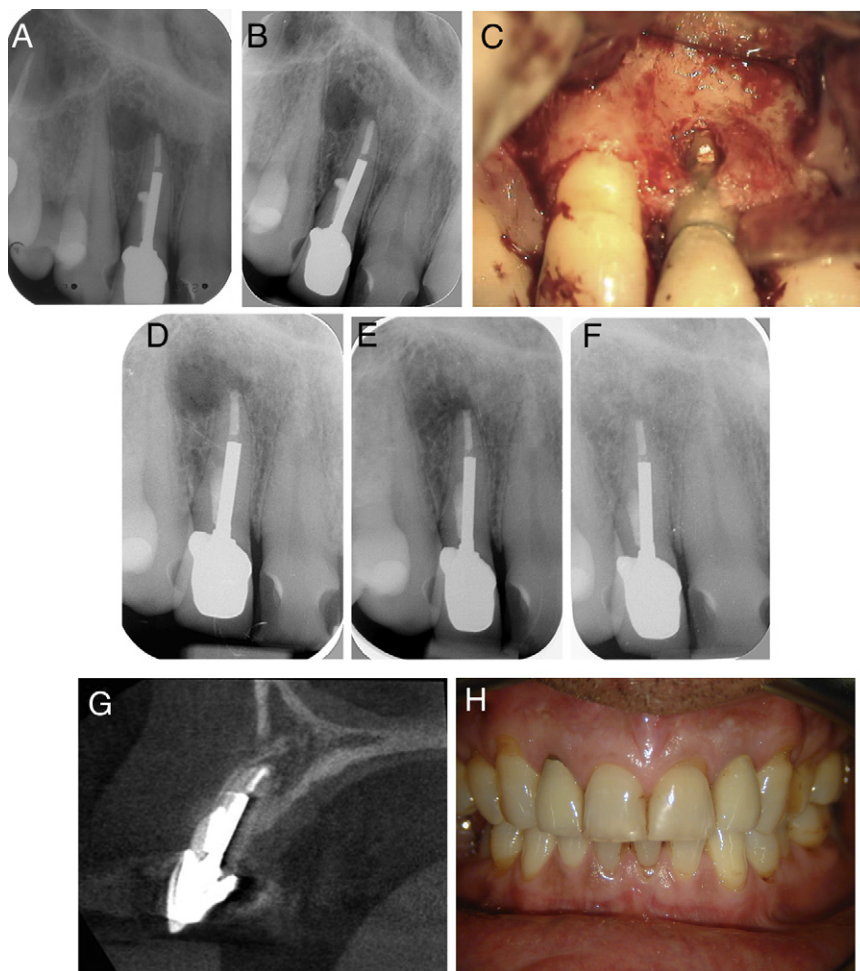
(A) A radiograph taken in 1999 showed periapical and lateral radiolucencies. The original treatment had occurred in 1984, and the treating dentist had filled the perforation with gutta-percha. (B) A radiograph of tooth #7 in 2003 before endodontic surgery. The lateral and apical radiolucencies did not appear to have reduced in size. (C) Surgical access was made with a full-thickness flap, the area was debrided, and the perforation site was visualized. (D) The perforation and root-end preparation were filled with MTA. (E) At the 1-year recall, there was a reduction of both radiolucencies. (F) At the 8-year recall, periapical radiographs showed no evidence of endodontic disease. (G) At the 8-year recall, cone-beam computed tomographic imaging showed no evidence of endodontic disease. A sagittal slice is shown. (H) A clinical photograph showing the metal-ceramic crowns 28 years after placement.
